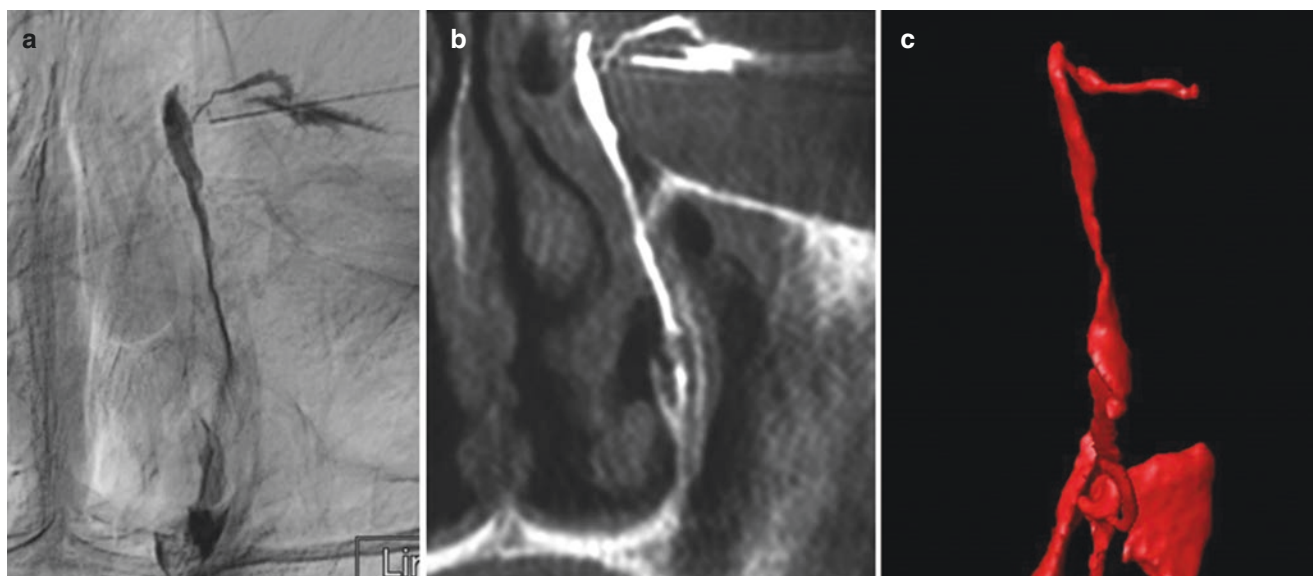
Cone beam CT-DCG: (a) is left eye frontal view of DCG; (b) is the coronal cut of a cone beam computer tomography dacryocystography (CBCT-DCG); (c) is a 3D surface-shaded display (3D-SSD) showing reconstruction of the lacrimal system offering superb anatomic details
